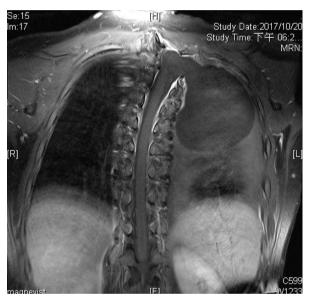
Two huge meningoceles were noted on the left side of the lower cervical and upper thoracic spine in the MRI of the thoracic spine.
